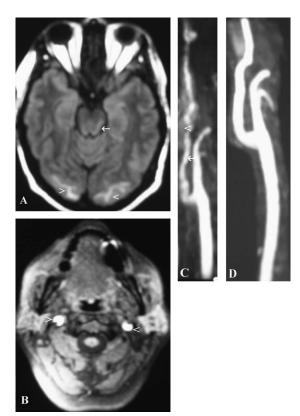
(A) MRI FLAIR image demonstrating posterior reversible encephalopathy syndrome in occipital lobes (arrowheads) with active MS plaques in pons (arrow). (B) MRI T1 fat suppressed image showing bilateral carotid artery dissections with bright signal in false lumen (arrowheads). (C) MRA of left internal carotid artery with false lumen (arrowhead) and true lumen (arrow). (D) Follow-up MRA of left carotid artery showing no evidence of dissection.
